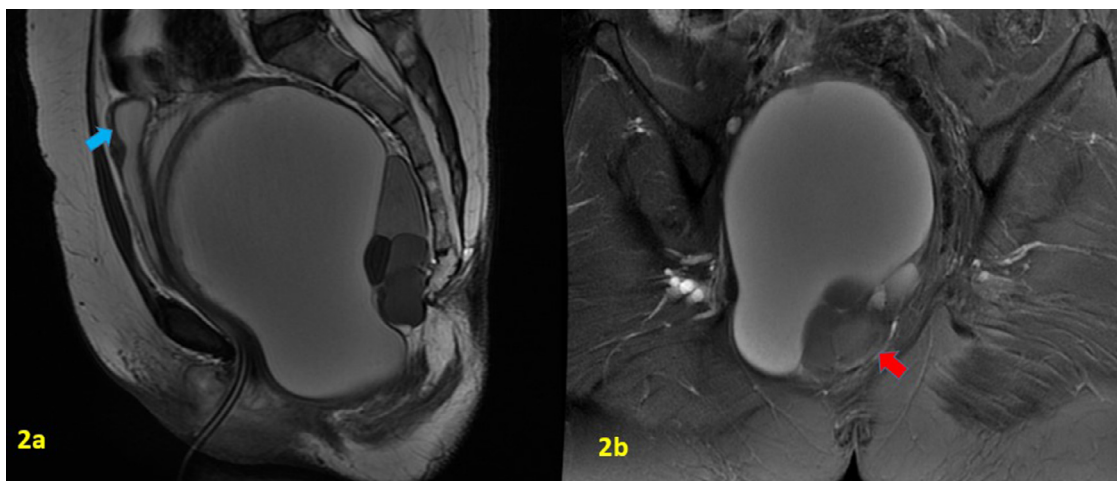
MRI pelvis – (A) sagittal section-T2 sequence showing multiloculated presacral cystic lesion with variable intensity in the loculi, displacing the urinary bladder anteriorly and upwards (blue arrow), (B) axial section showing displacement of the rectum towards left side (red arrow).
